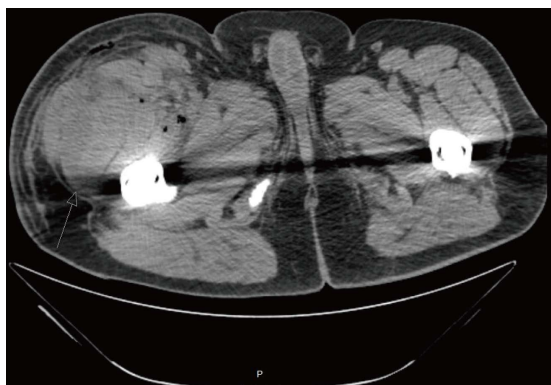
Transverse plane computed tomography scan showing a hematoma dorsally in the anterior compartment.
